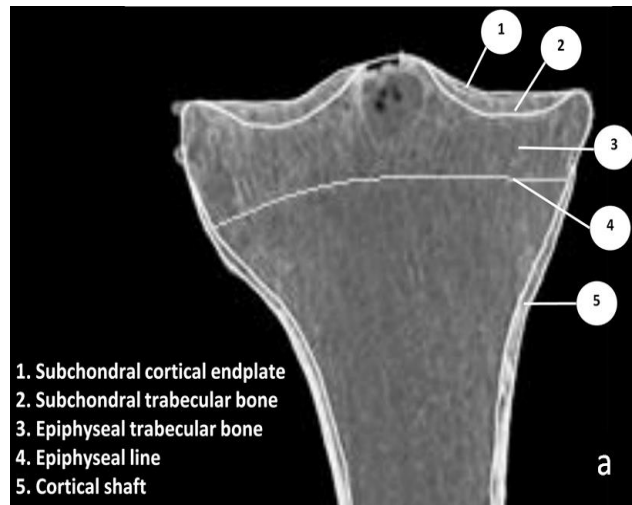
Sagittal CT image of the proximal tibia (a). Layers of the subchondral bone include subchondral cortical endplate, subchondral trabecular bone, epiphyseal and metaphyseal trabecular bone and the cortical shaft. Different layers of the cartilage-subchondral bone complex (b). Articular cartilage is distinguishable from the underlying calcified cartilage and subchondral bone by the tidemark. From Madry et al. [42] with permission from Springer.
